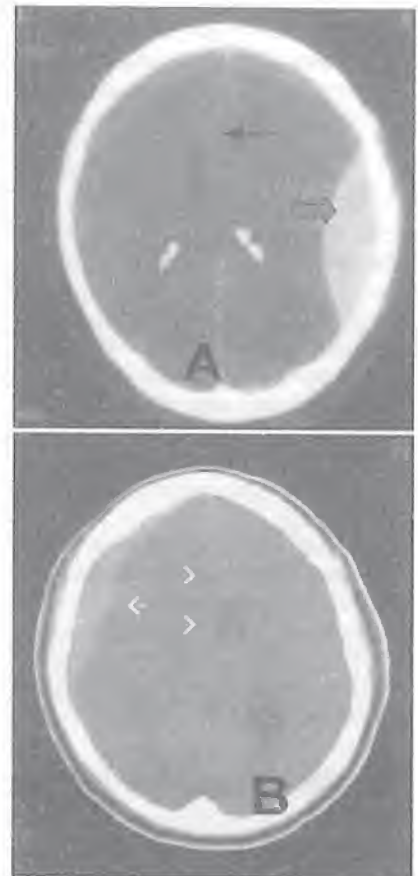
On CT scan, acute haematomas appear hyperdense.
